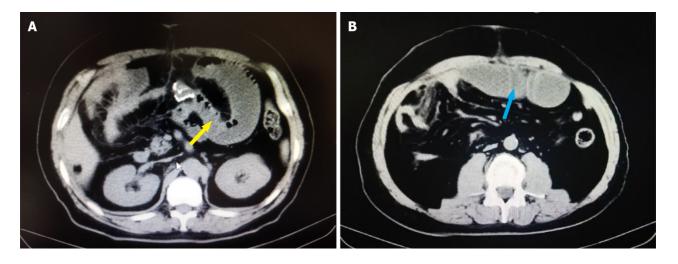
Abdominal computed tomography revealed intestinal obstruction of the patient after abdominal surgery. A: The yellow arrow indicated the patient's intestinal obstruction at the right renal hilus level; B: The blue arrow indicated the patient's intestinal obstruction at the umbilical level.
